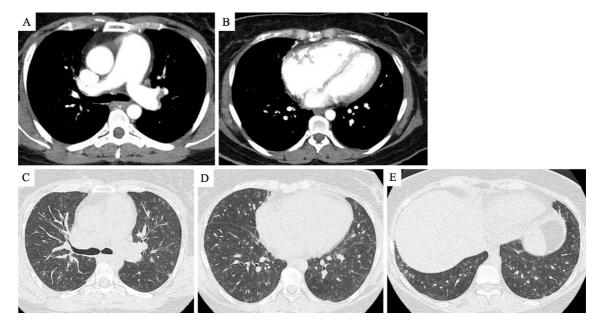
Computed tomography findings of the chest. A-B) Contrast-enhanced computed tomography findings showing dilatation of the bilateral pulmonary arteries and right heart. No thrombus was visible in the pulmonary arteries. C-E) Centrilobular ground-glass opacities are visible in both lungs. Pleural effusion was not detected.
